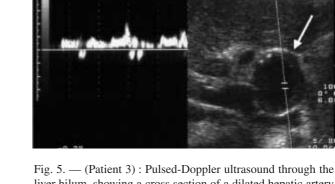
(Patient 3) : Pulsed-Doppler ultrasound through the liver hilum, showing a cross section of a dilated hepatic artery with mural thrombus and calcifications of the wall (arrow). The arterial signal is deformed.
